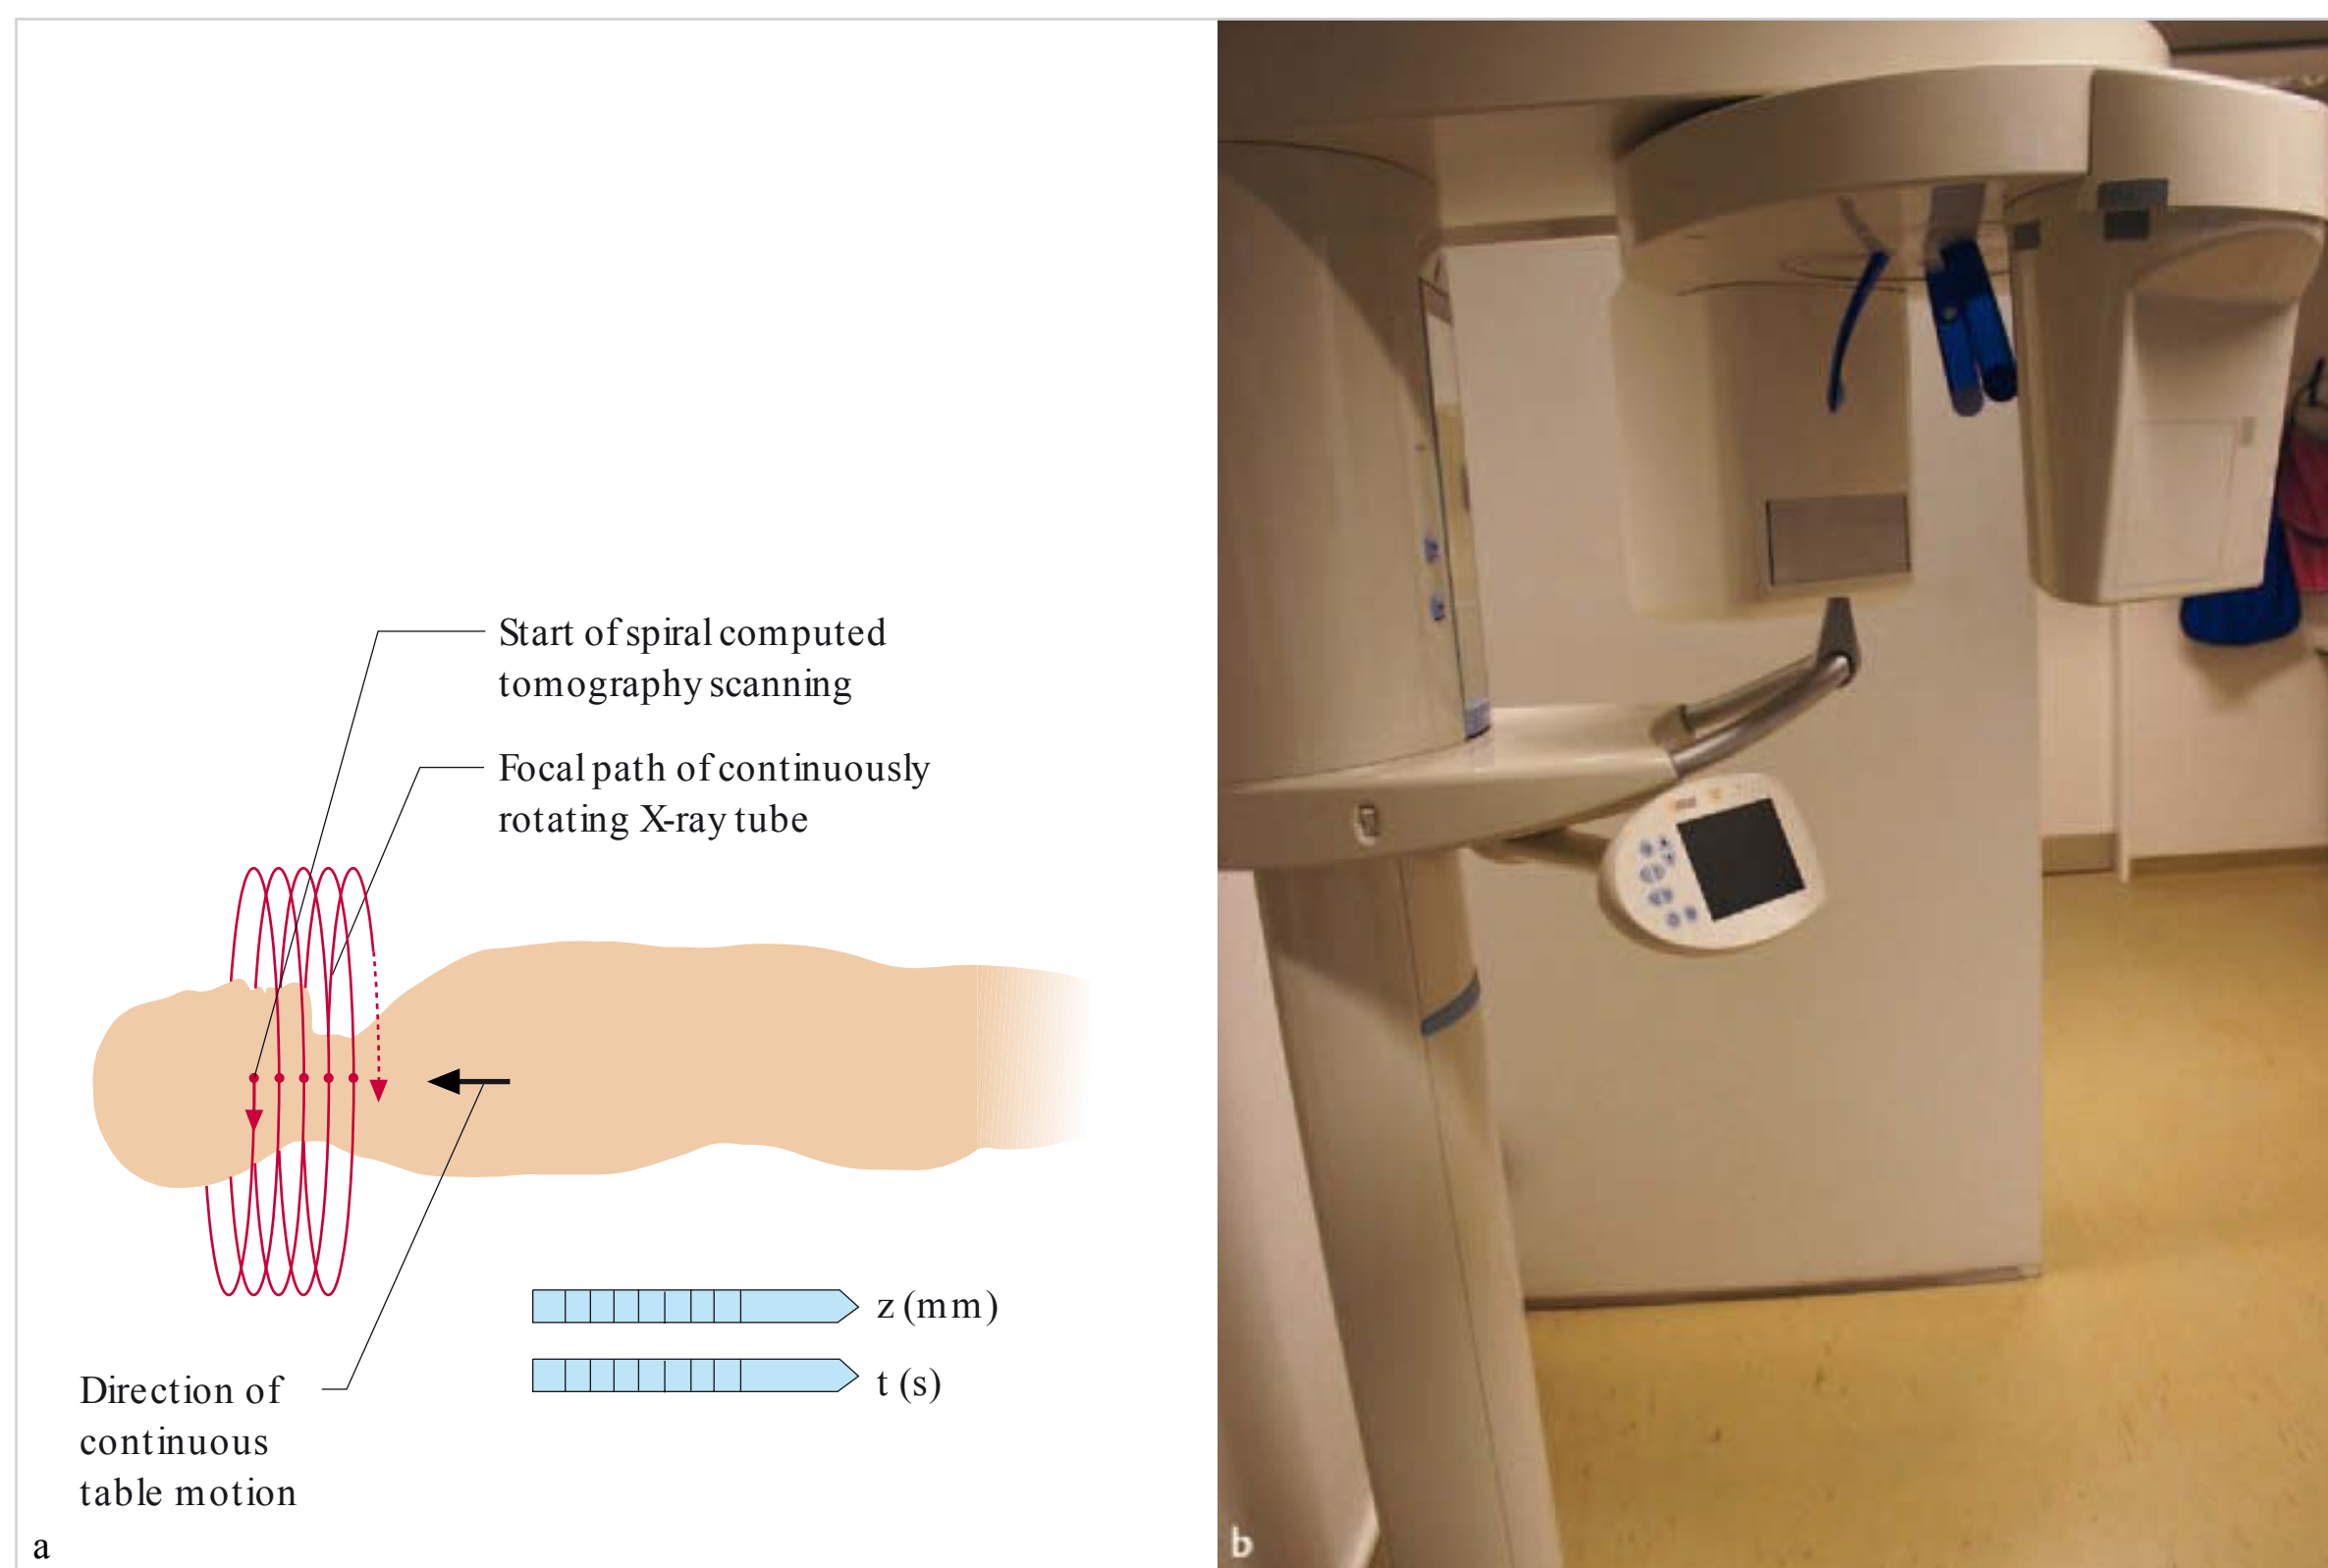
Spiral computed tomography.
